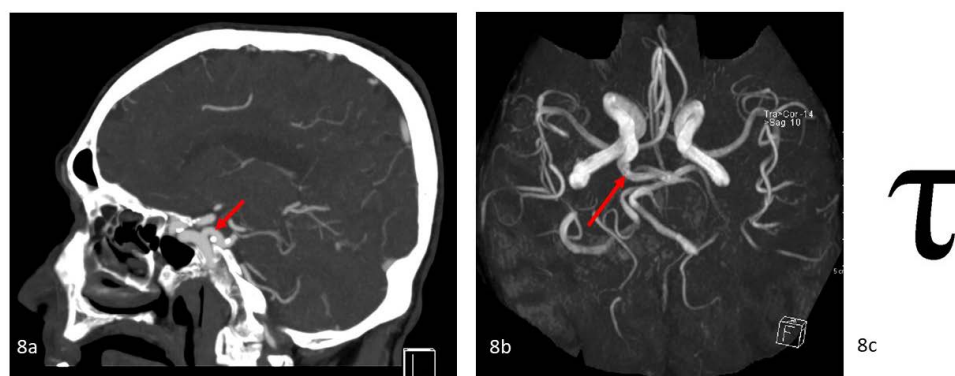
Tau sign. 73 year old male with right persistent primitive trigeminal artery. (8a) CT angiography of the Circle of Willis sagittal reformats show a persistent trigeminal artery (red arrow), forming the Greek letter ‘τ’ (tau). Siemens Somatom Force, 80 kV, 239mAs, Intravenous contrast: 60 ml Omnipaque 350. (8b) Time of flight MR angiography 3D volume-rendered reconstruction of the Circle of Willis shows a large-calibre artery (red arrow) arising from the ICA and joining the basilar artery tip, consistent with right persistent primitive trigeminal artery Saltzman type I. Siemens Aera, 1.5 Tesla, TR 24 TE 7 FA 25. (8c) Greek letter ‘τ’ or tau.
